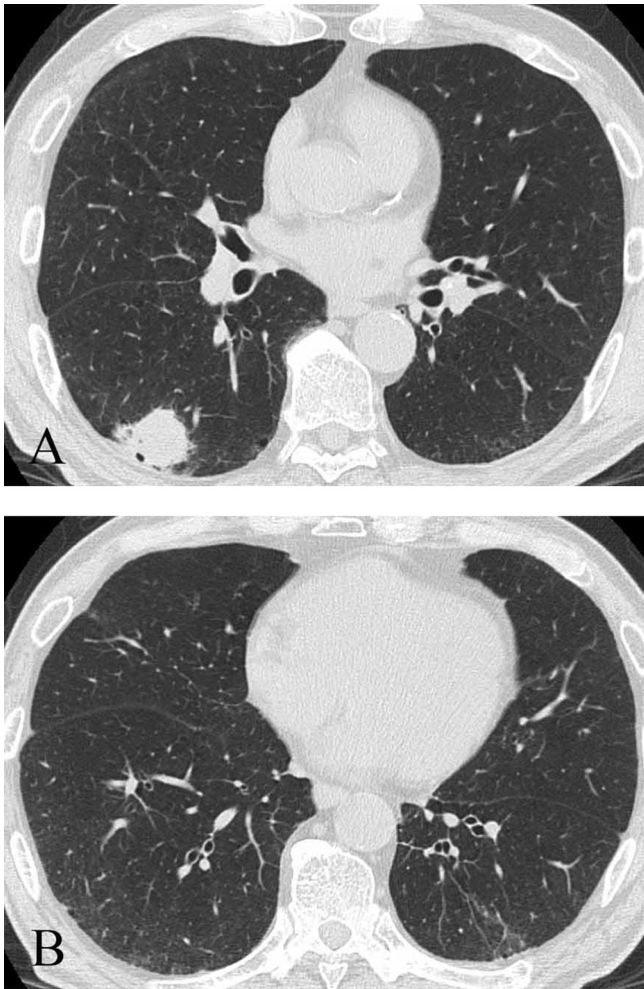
High-resolution computed tomography (HRCT) before the first surgery. HRCT of the chest revealed a nodule in the right lower lobe (A) and ill-defined centrilobular small nodules and ground-glass opacities, in addition to low attenuation areas and small cysts, in the subpleural areas bilaterally (B).
